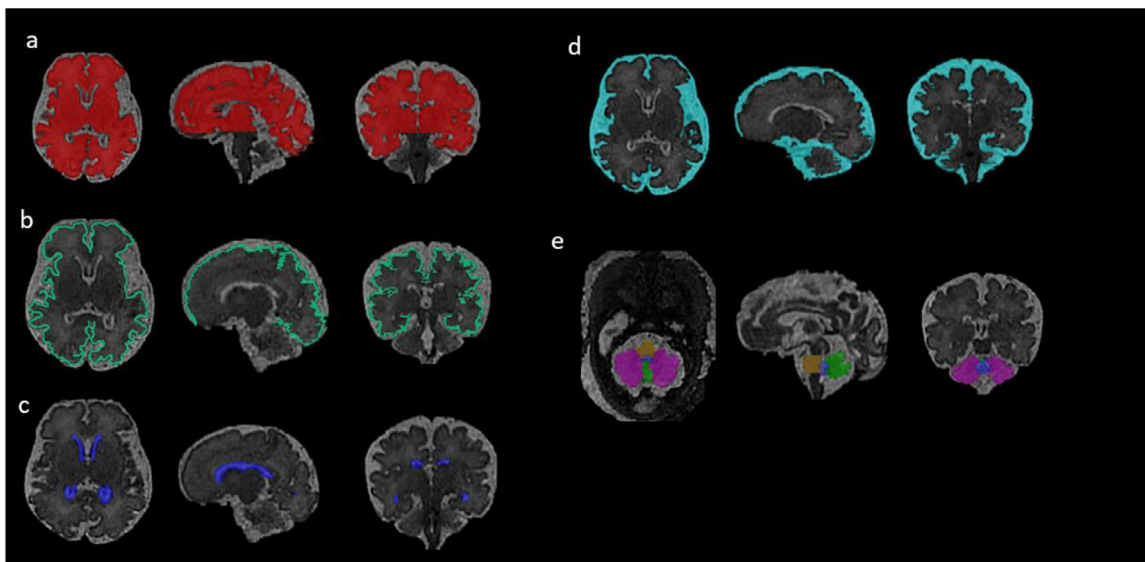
Volumetric segmentation of the fetal brain. Segmentation of T2-weighted volumetric MR images in the axial, sagittal and coronal planes showing (a) supratentorial brain tissue (red), (b) cortex (green), (c) lateral ventricles (dark blue), (d) extra cerebral cerebrospinal fluid (light blue); and (e) cerebellar hemispheres (pink), cerebellar vermis (bright green), pons (yellow) and fourth ventricle (blue).
